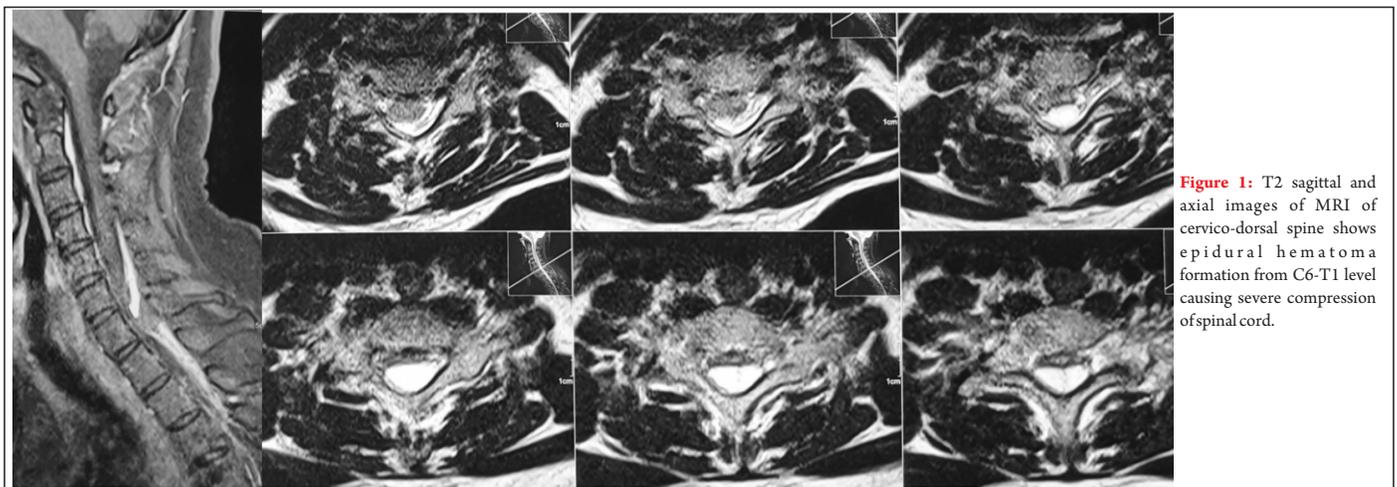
T2 sagittal and axial images of MRI of cervico-dorsal spine shows epidural hematoma formation from C6-T1 level causing severe compression of spinal cord.
